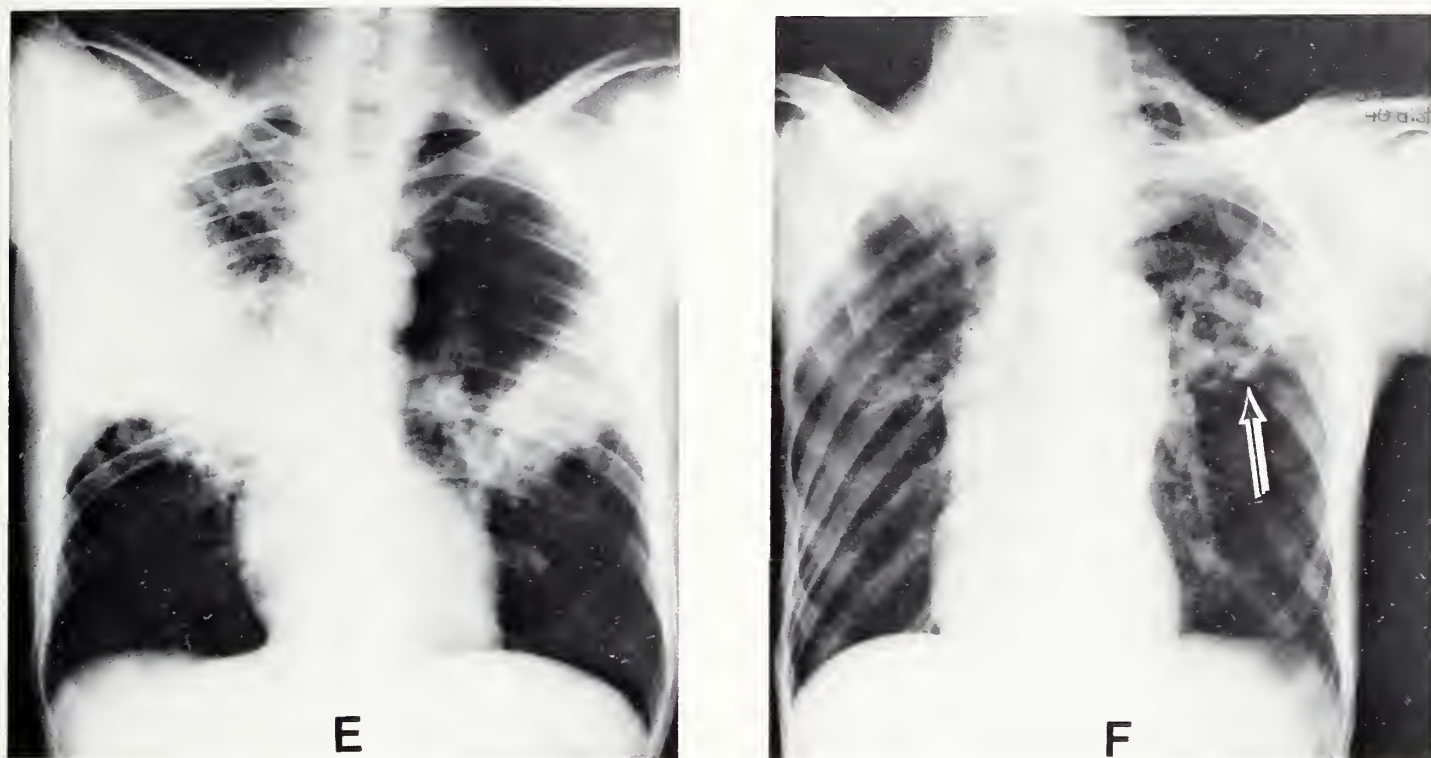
CHEST X-RAYS OF PATIENTS WITH PREVIOUSLY-UNDIAGNOSED TUBERCULOSIS WITH "SUBTLE" OR "ATYPICAL" PRESENTATIONS.
